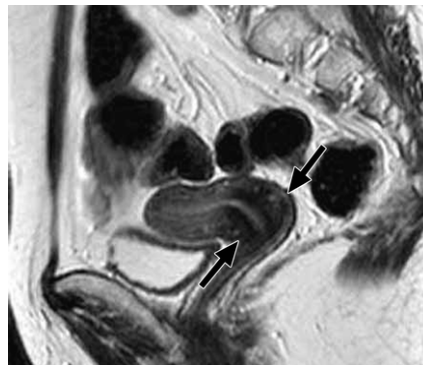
Postmenopausal uterus. Sagittal T2-weighted image shows a small uterine corpus that is almost the same size as the cervix (arrows). The zonal anatomy of the corpus is indistinct (*Quoted from Izumi et al., 2003*).
